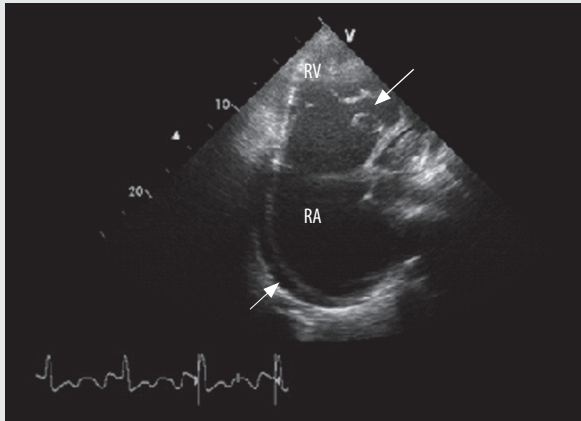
Echocardiography. Four chamber view. Apical displacement of septal and posterior leaflets of the tricuspid valve (25.5 mm, 8.8 mm/m²) (big arrow). Small pericardial effusion (small arrow). RA – right atrium, RV – right ventricle
